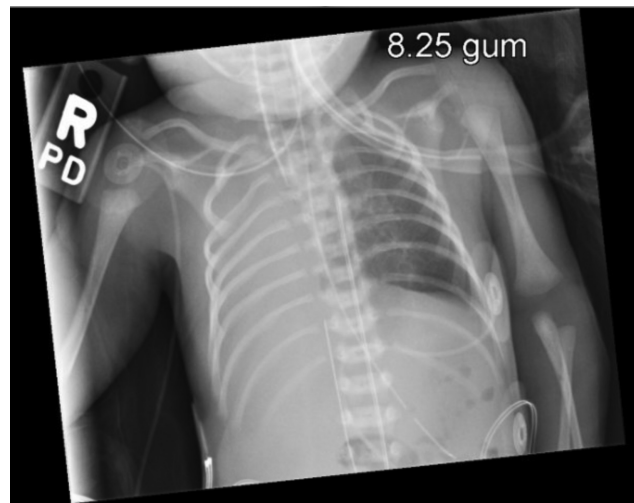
Chest X-ray of first case showing opacification of left hemithorax.
